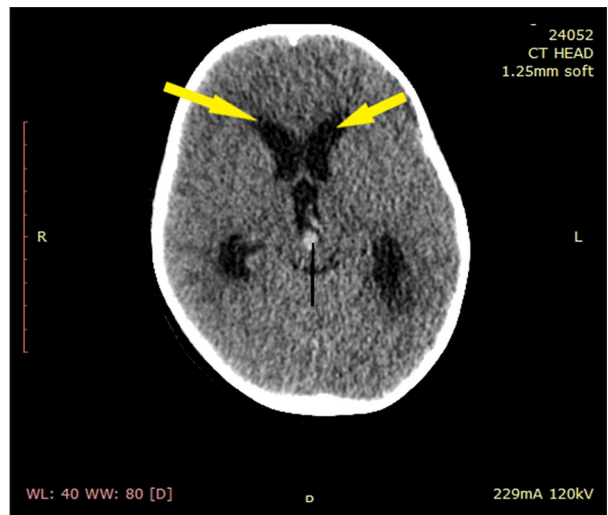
Same CT scan as Figure 3 depicting blood clot within the third ventricle and the dilation-rounding of the frontal horns, indicative of ongoing hydrocephalus. CT – computed tomography.
